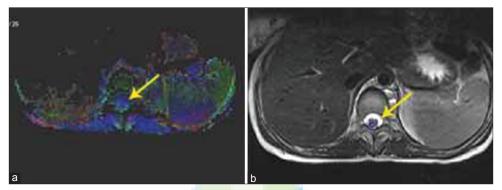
(a) Region of interests at serial intervals (yellow arrow) drawn below the site of lesion. (b) Corresponding axial T2 magnetic resonance imaging shows no epidural collection
